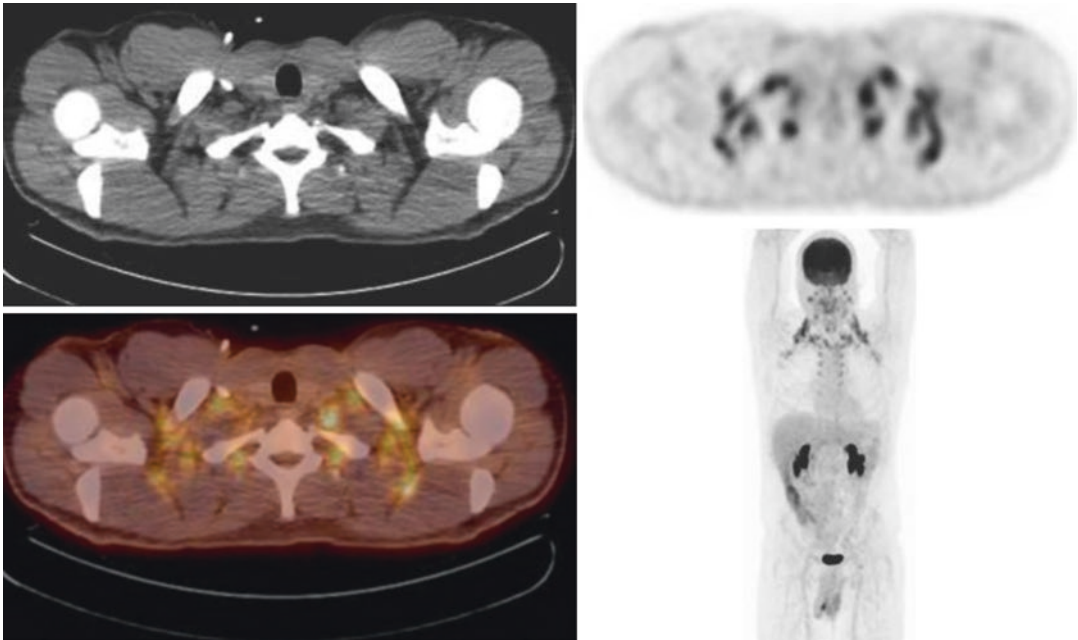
A 34-year-old male with a history of colon cancer. PET/CT images demonstrate diffuse symmetric FDG uptake within the bilateral neck, supraclavicular, and axillary regions due to brown fat activity
